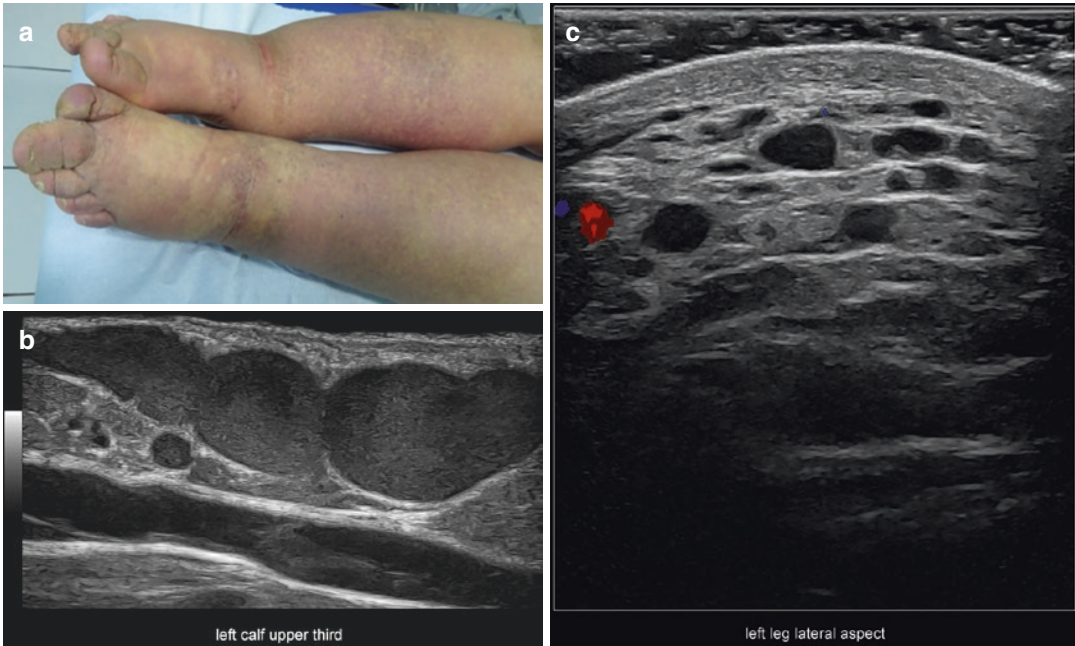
Klippel-Trenaunay syndrome. (a) Clinical image. (b) Grayscale ultrasound (longitudinal view; left upper third of the calf) demonstrates several dilated and tortuous hypodermal veins. (c) Color Doppler ultrasound
